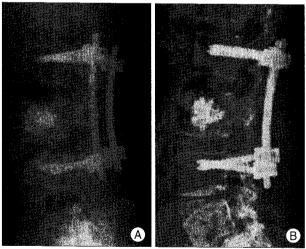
Postoperative radiographs: X-ray on the first day after the operation (A) showing the injected PMMA cement on the L3 vertebral body, total laminectomy of L3, and L2-4 pedicle screw fixation. A follow-up X-ray ten months later (B) doesn't show any further bony destruction.
